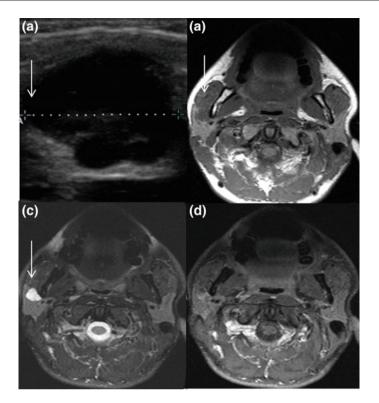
Pleomorphic adenoma. a Ultrasound. On US, the lesion is a lobulated hyperechoic solid mass. b Axial T1 fat pre-contrast image demonstrating a hypointense mass in the anterior right parotid gland (arrow). c Axial T2 image demonstrates well-circumscribed T2 hyperintense lesion in the anterior superficial aspect of the right parotid gland (*arrow*). d Axial T1 post-contrast image demonstrates heterogeneous enhancement
